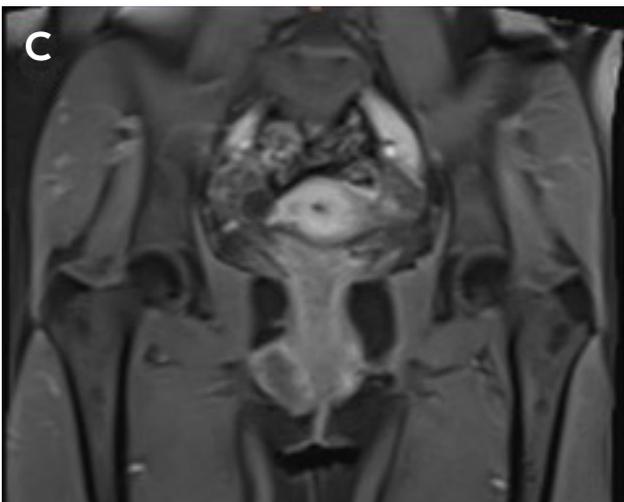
MRI. Dynamic study.
